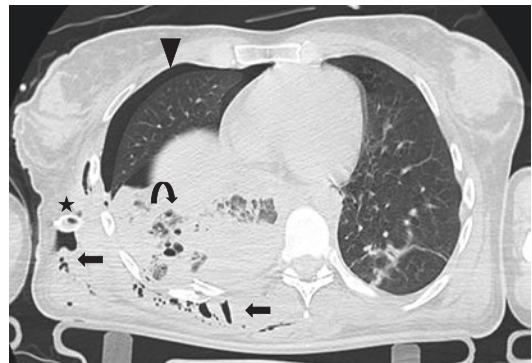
CT axial imaging of the same patient showing subcutaneous emphysema (*arrow*) of the right chest wall, lung contusions (*curved arrow*). Right pneumothorax (*black arrowhead*). Chest tube placement (*star*)
